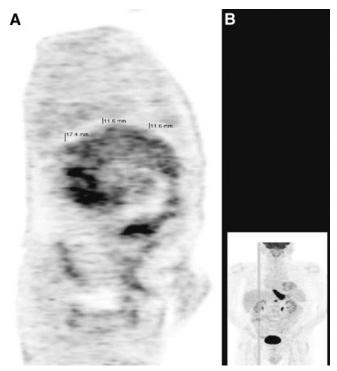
(A) Example of respiratory artifact that can be seen on PET/CT images obtained when patients breathe quietly. Moderate-sized "cold" area (above liver) was curvilinear and resulted from mismatch of top of liver on PET (free tidal breathing) (B) and CT (more full inspiration in this case). Cold area was actually part of liver, not lung. (Image courtesy of M. Olman).
